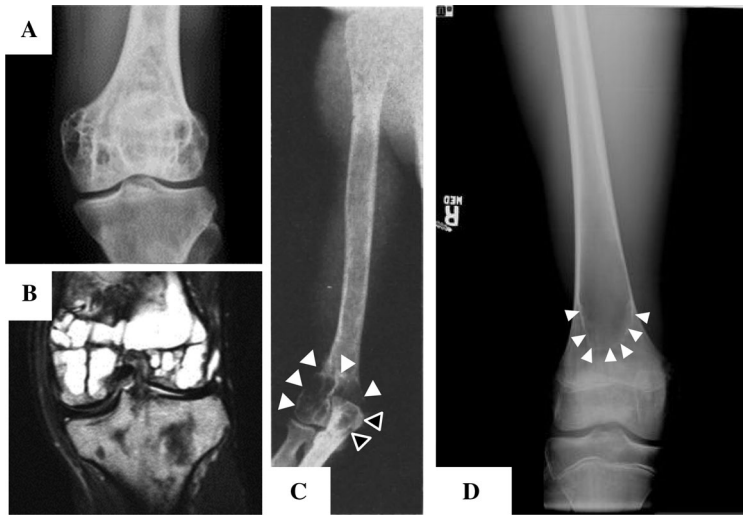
Osteolytic skeletal lesions in CGL and AGL. (A), (B) Multicystic transformation of the distal femur in a 42-year-old Kurdish woman with CGL.⁵⁴ The lesion remained relatively unchanged between age 31 and 42 and showed coarse trabeculation of cystic areas filled with high, fluid-like signal intensity on T2-weighted MRI images.⁵⁴ (C) Bilateral lesions of the distal humeri, distal radii, proximal and distal ulnae, and phalanges of the hand were noted in a 17-year-old female with CGL that became progressively worse by age 22 and resulted in pathologic fracture of the right humerus at age 23 and the left forearm at age 24.⁴⁷ Lesions of the left distal humerus (white arrows) and proximal ulna (black arrows) are shown in panel C. (D) Bilateral unicameral bone cysts of the femoral diaphysis (right femur pictured) in a 13-year-old male with acquired general lipodystrophy.⁶¹ Distal extension noted by the white arrows.
